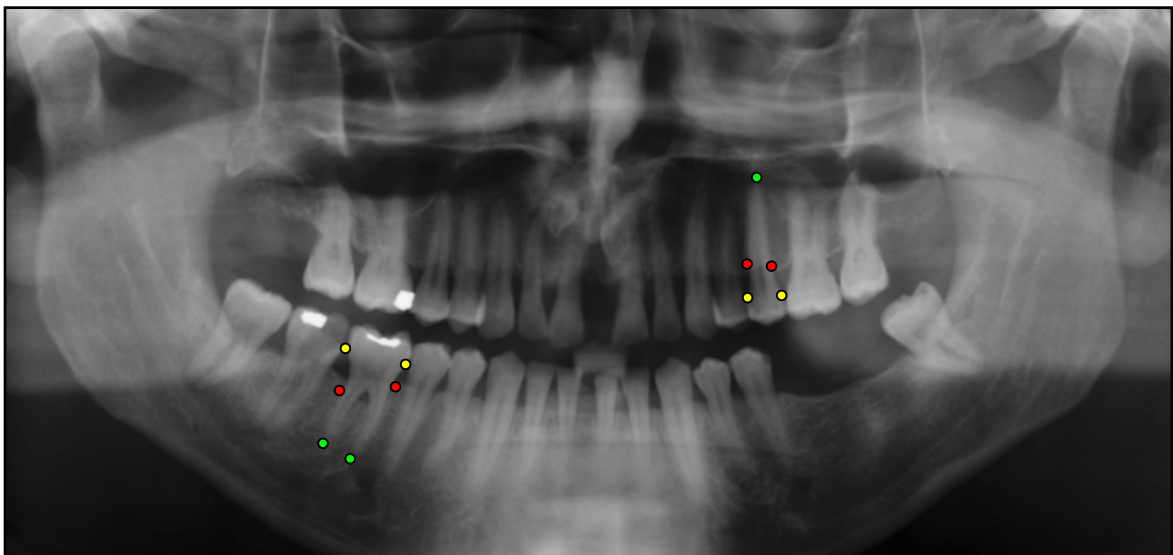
Example of the digital panoramic radiograph with the land marks.
